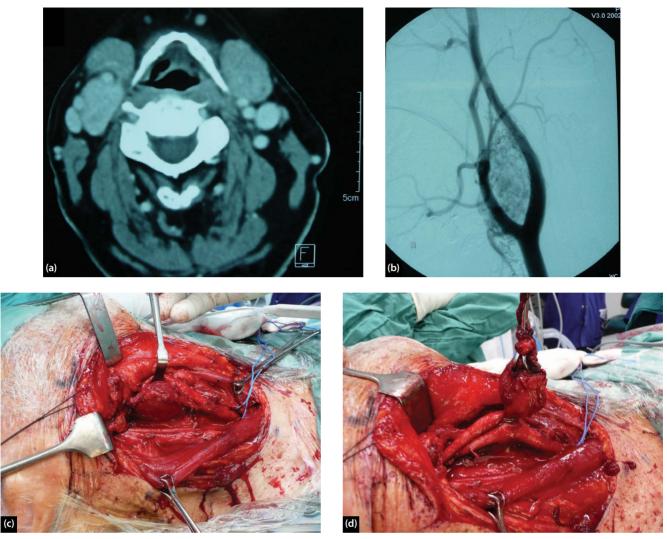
(a) CT neck showing vascular right carotid body tumour lying between internal and external carotid arteries. (b) Angiogram showing vascular right carotid body tumour splaying Internal and external carotid arteries – the 'Lyre' sign. (c) Right carotid body tumour. (d) Right carotid body tumour dissected off internal and external carotid arteries.
